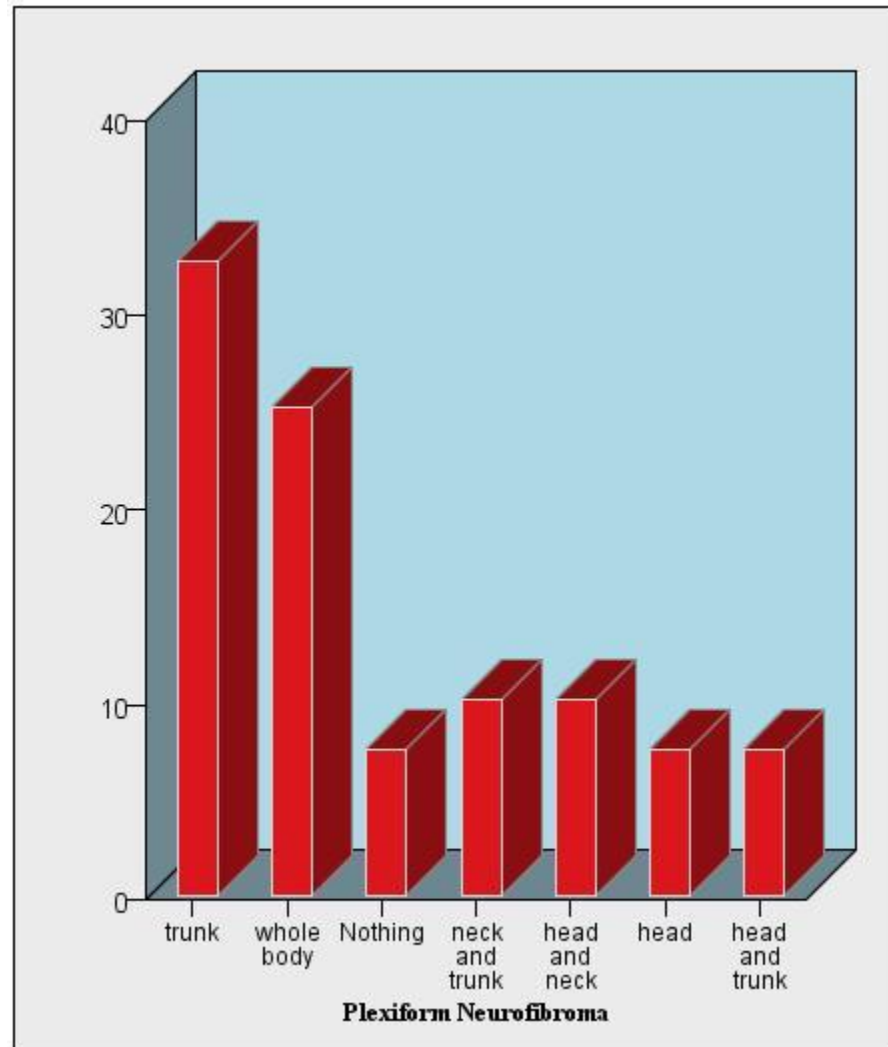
Location of the plexiform neurofibromas confirmed by MRI findings performed in 40 NF1 individuals.
